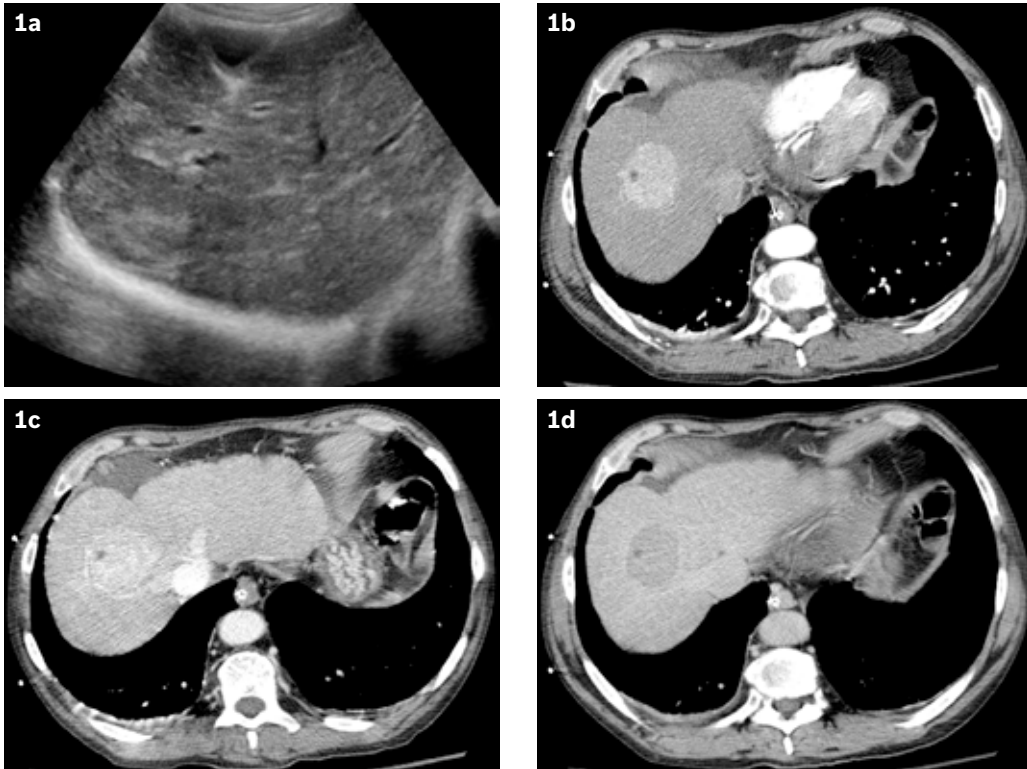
(a) Abdominal US image shows a solid mass in the right hepatic lobe. (b) Hepatic arterial phase CT image shows a hypervascular mass with a small hypodense area. (c) Portal venous phase CT image shows the tumour remaining hypervascular to the liver. (d) Delayed phase CT image shows tumoural washout of the contrast, relative to adjacent liver parenchyma, compatible with a hepatocellular carcinoma.
